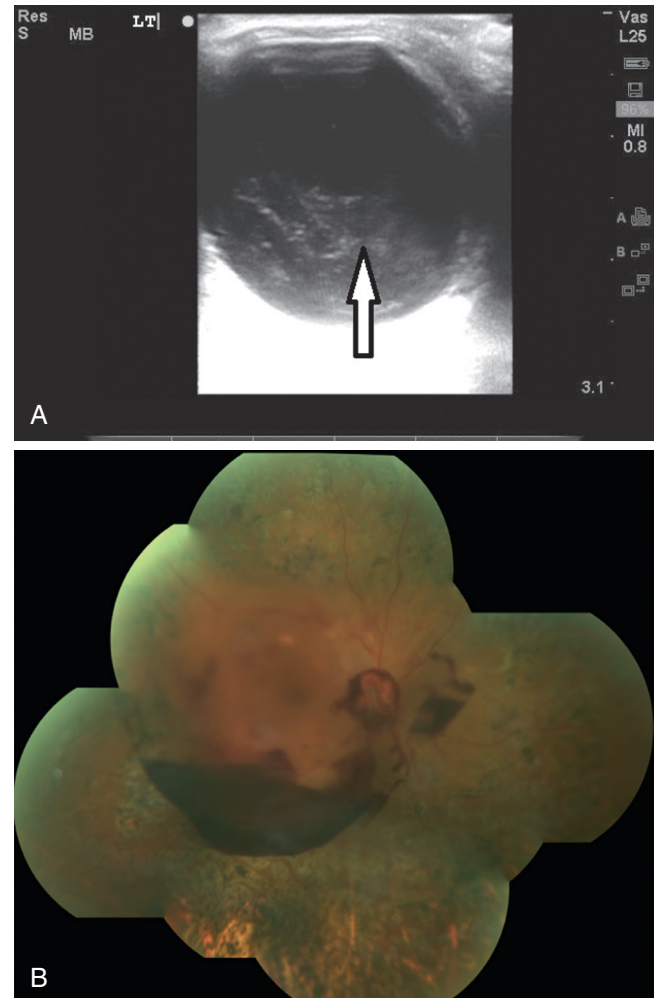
A, Ocular ultrasound showing vitreous hemorrhage (white arrow). B, Boat shaped pre-retinal vitreous hemorrhage (A, Courtesy Douglas Brunette, MD. B, Courtesy Jeffrey Lee, MD.)
